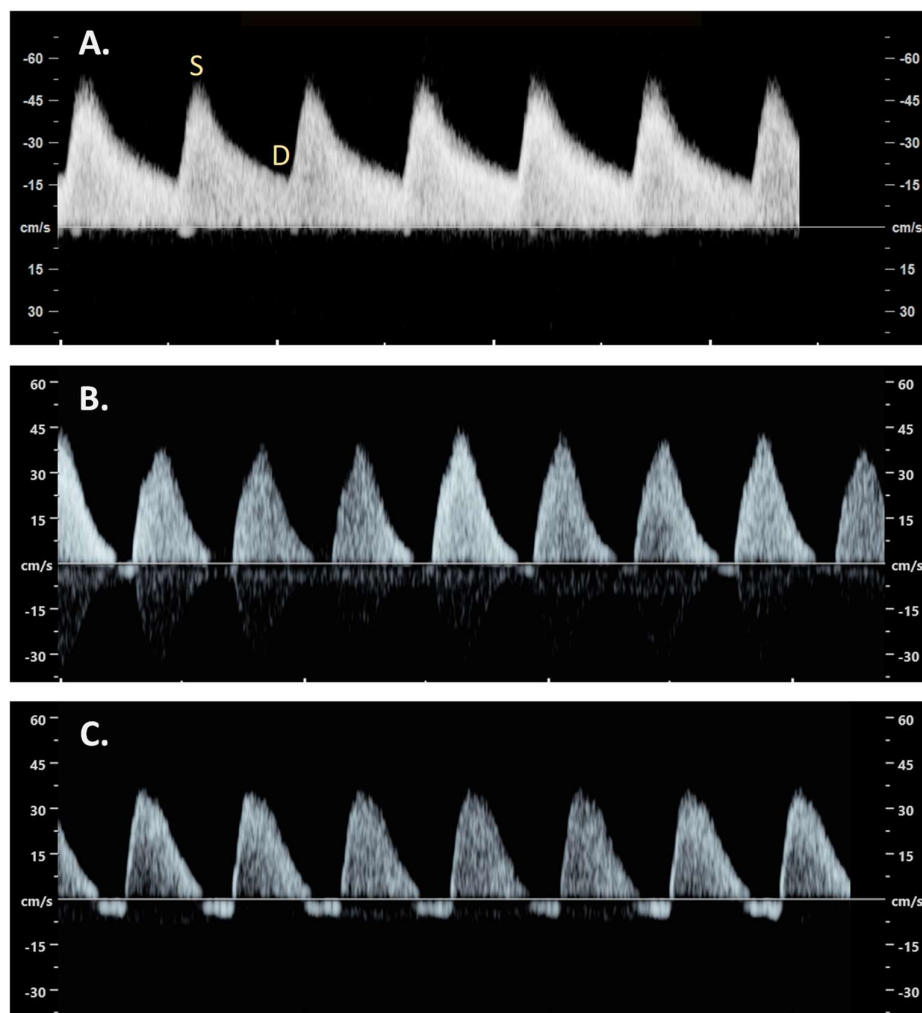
A. Normal Doppler waveform of the umbilical artery imaged with contemporary ultrasound equipment. S is the peak systolic velocity and D is the least diastolic velocity. B. Umbilical artery Doppler waveform depicting absent diastolic flow C. Umbilical artery Doppler waveform depicting reversal of diastolic flow. Images produced by D Paoletti.
